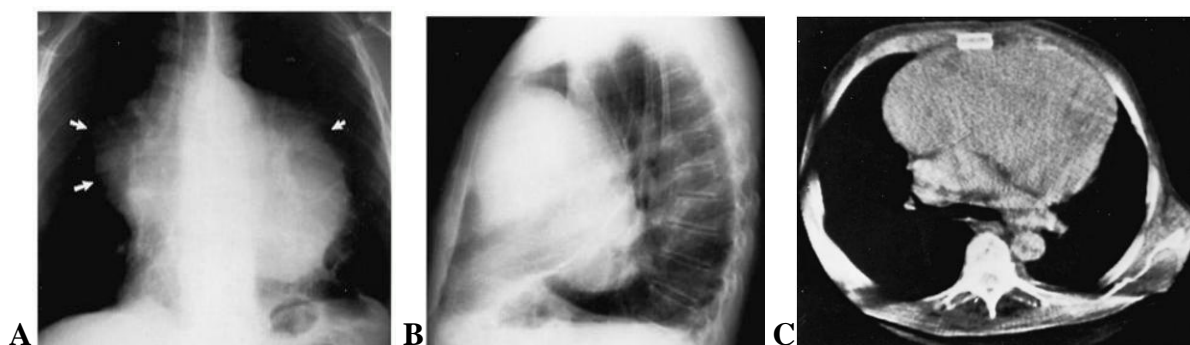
Thymoma. (A) Frontal view shows a large bilateral lobulated mass (arrows) extending to both sides of the mediastinum. (B) Lateral view shows filling of the anterior precardiac space by a mass and posterior displacement of the left side of the heart. (C) On CT axial tomogram enormous soft-tissue mass in the anterior mediastinum with posterior displacement of other mediastinal structures. No difference in density can be seen between the mass and the heart behind it
